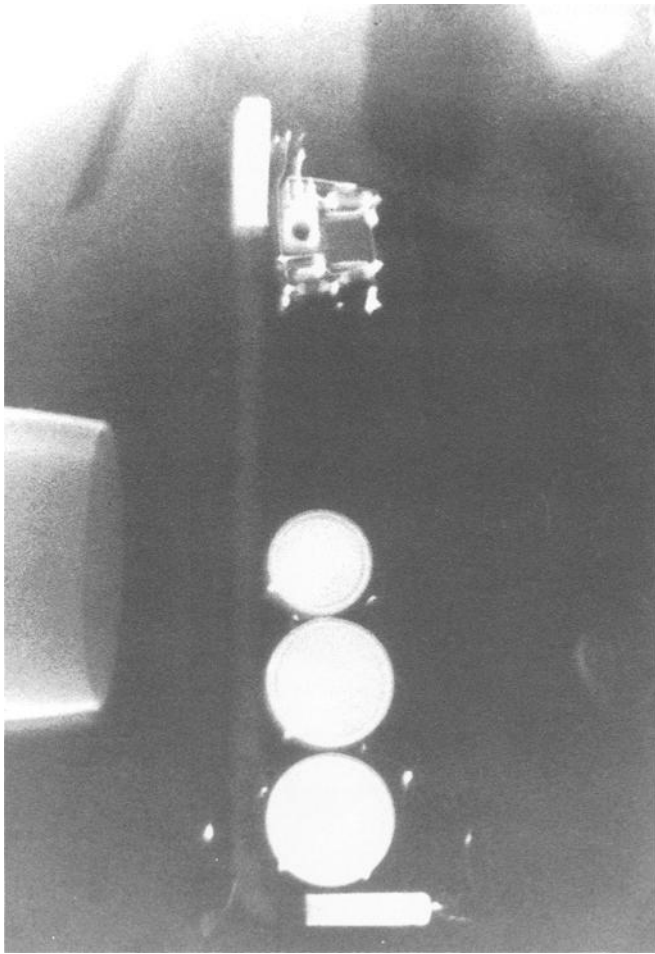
X-Ray of the bomb showing button cell batteries and metal sleeve of the fuse.
